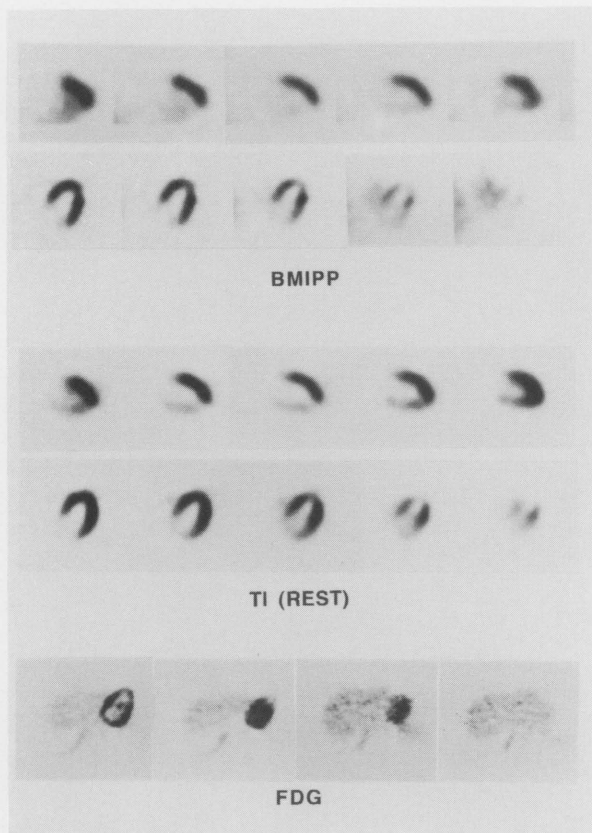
61-year-old woman with inferior MI after 20 months from onset. Coronary arteriogram revealed 100% stenosis of RCA #2 with collateral circulation from LAD and LCX. Left ventriculogram showed hypokinesis of Seg. 4 and Seg. 5. A series of vertical long-axis slices of BMIPP images (Top) and TI images (Middle), and a series of axial slices of FDG PET images (Bottom). BMIPP uptake is less than TI uptake in the inferior region, where FDG uptake was observed on PET images.
